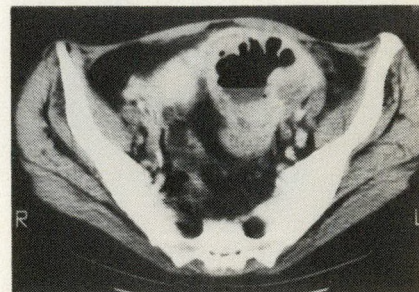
Computed tomogram demonstrating gas-containing left adnexal mass.
